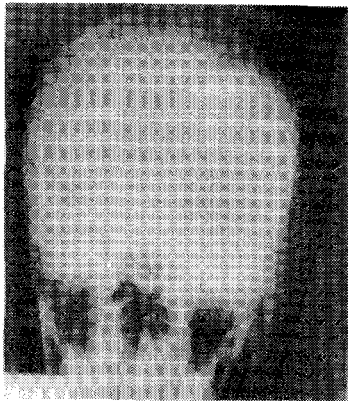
Posterior anterior radiograph of the skull showing intracranial extension as a radio-opaque area.
